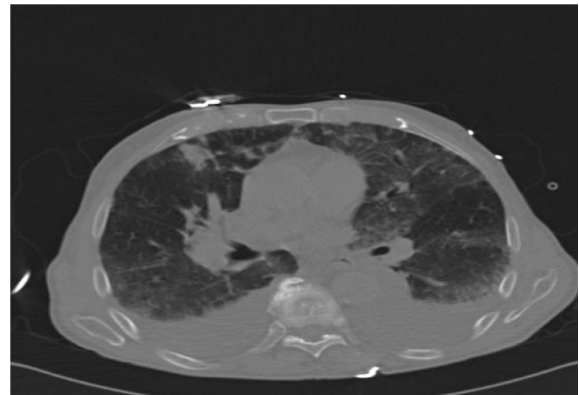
Computed tomography of the chest revealed diffuse bilateral airspace disease with ground glass attenuation involving all lobes along with moderate bilateral pleural effusions.
